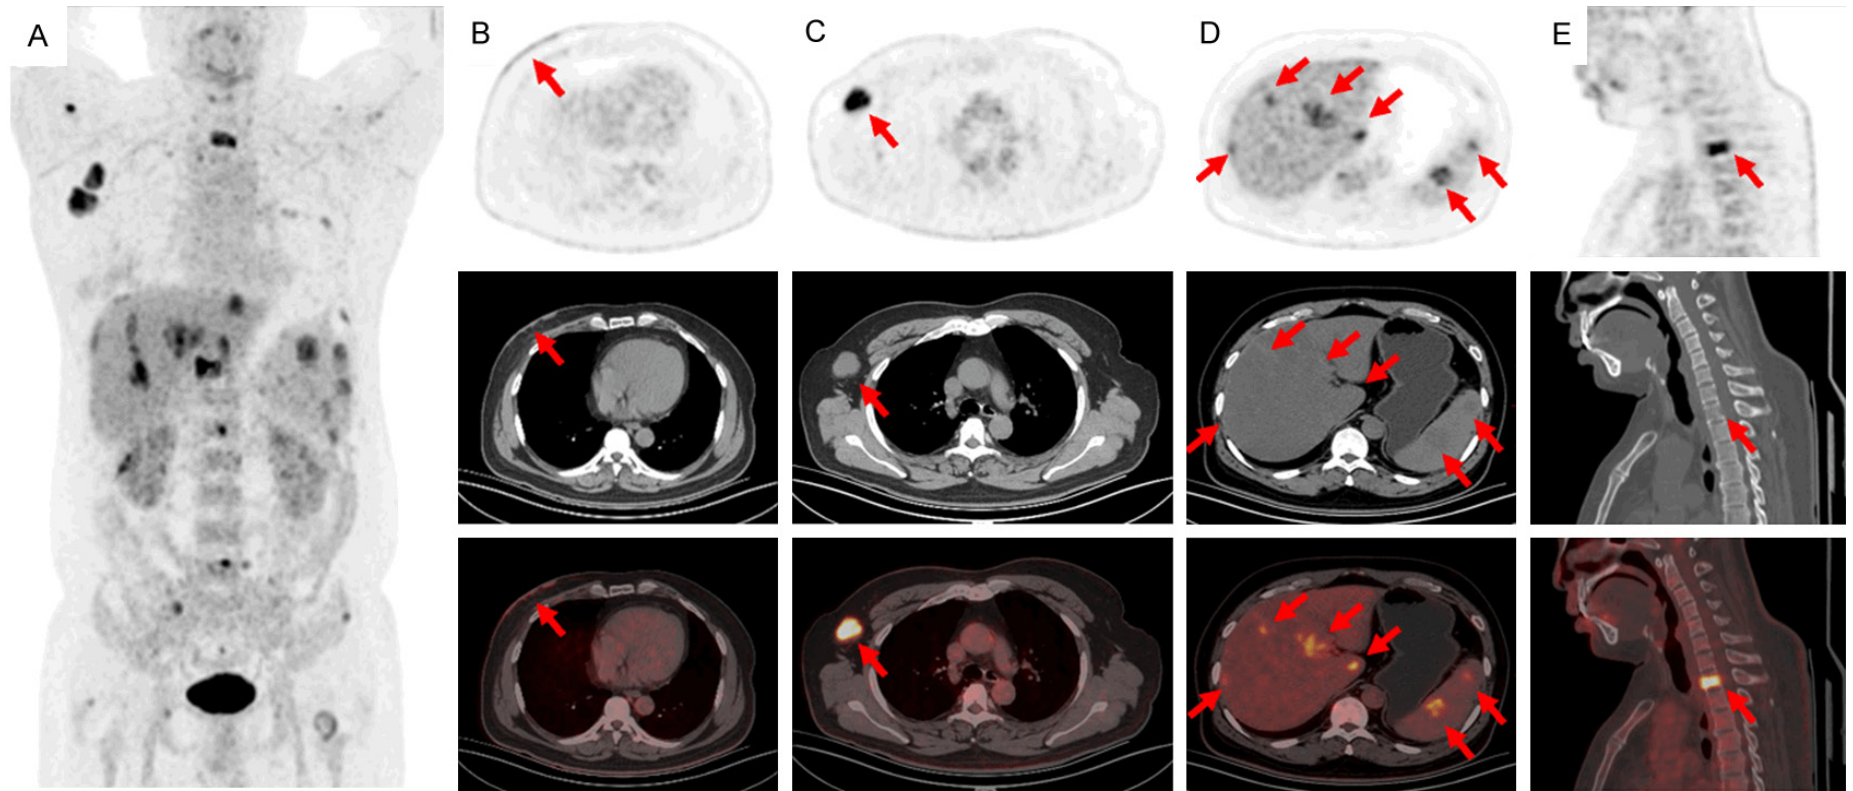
^{18}F -FDG PET/CT images of a patient after systemic progression in pcALCL. (A) The whole-body maximum intensity projection showed multiple areas of high FDG uptake throughout the body. (B-E) The anterior chest wall (B), right axillary lymph nodes (C), liver, spleen (D), and bones (E) showed multiple areas of high FDG uptake.
